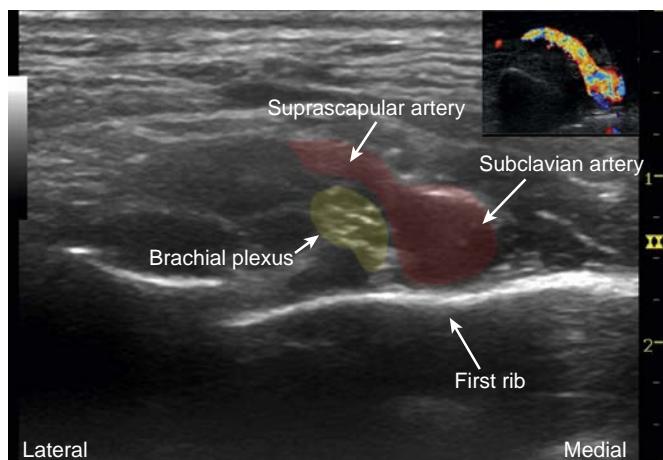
Ultrasound supraclavicular block imaging and surrounding vessels by using color Doppler.
